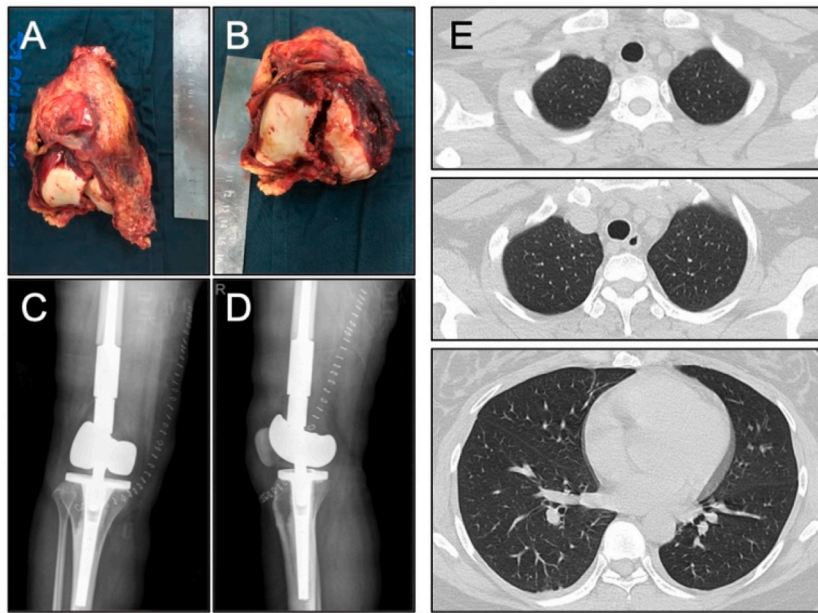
The post-operative inspection of the patient in the surgical site and lung. A-B showed the overview of the resected tumor tissue and distal femur. C-D showed that the joint prosthesis was placed in the resected area by X-ray. E showed no metastasis was seen in the lung by CT.
